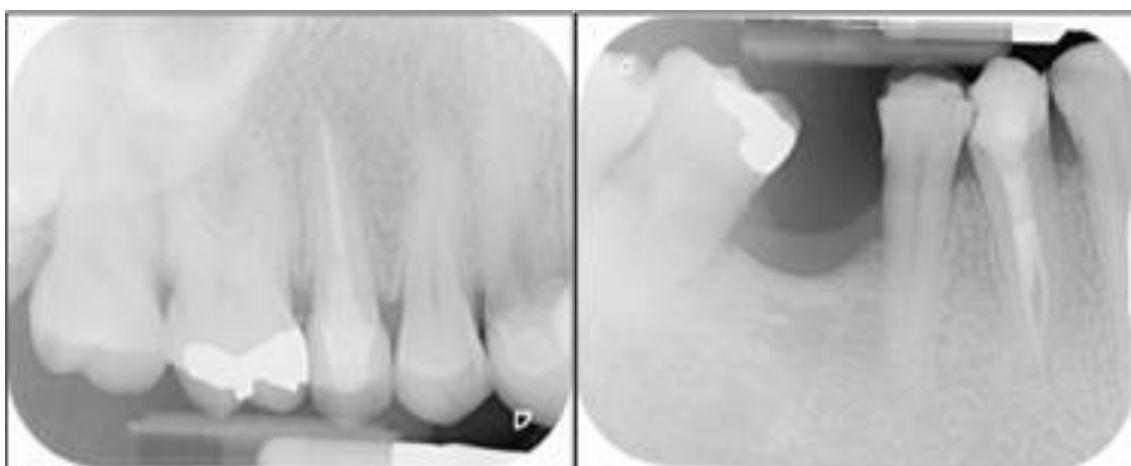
Post-endodontic radiographs showing completed endodontic treatment and post crown of tooth 15 and completed endodontic retreatment of tooth 44 with satisfactory obturations.
